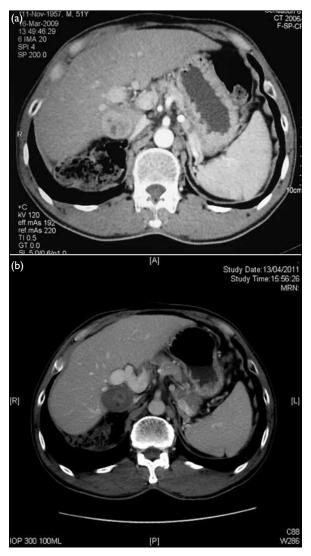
(a) Recurrent hepatocellular carcinoma between portal vein (front) and inferior vena cava (behind). (b) Post-ablation appearance of the same tumour on computed tomography
